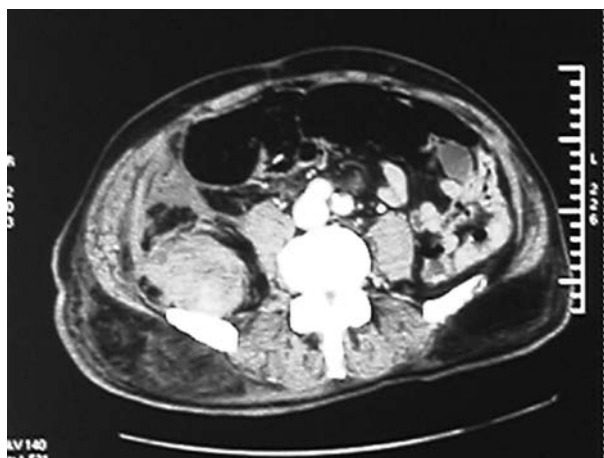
CT: a right gluteus maximus hematoma
